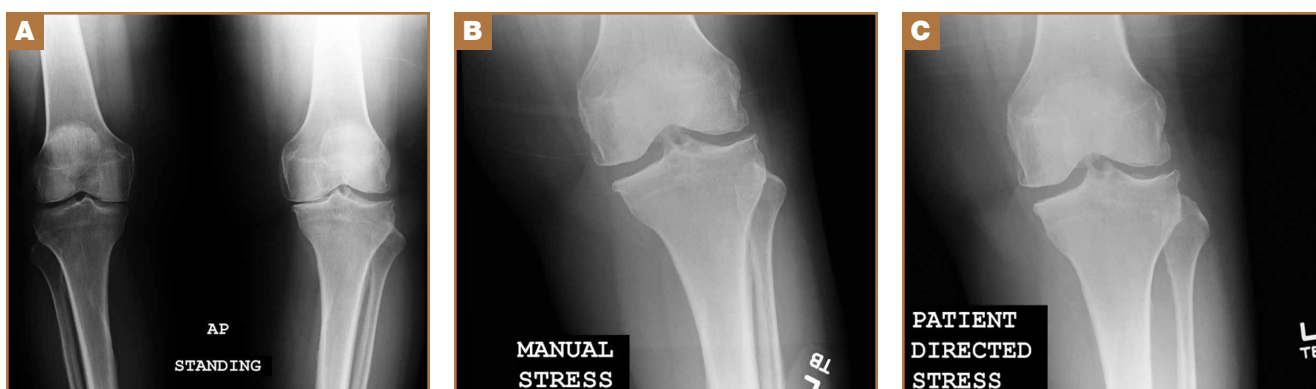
(A) Standing anteroposterior radiograph of knees. (B) Manual stress view of left knee. (C) Patient-directed stress view of left knee.
